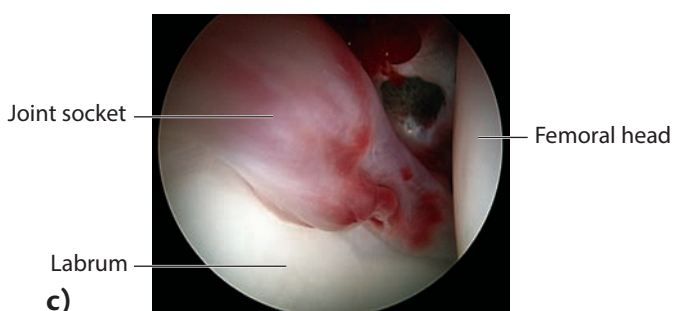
Arthroscopy of the hip joint. a) Patient positioning: the procedure is performed on an extension table, where the hip joint can be extended and the joint be widened; b) monitoring of the hip joint can be performed using X-rays and arthroscope TV monitor and fluoroscopy (this is an imaging technique that allows the physician to see the internal structure and function of a patient); c) a labrum injury can be diagnosed and treated with the aid of arthroscopy (courtesy of Prof. Marc Safran, Stanford University, California, USA).
